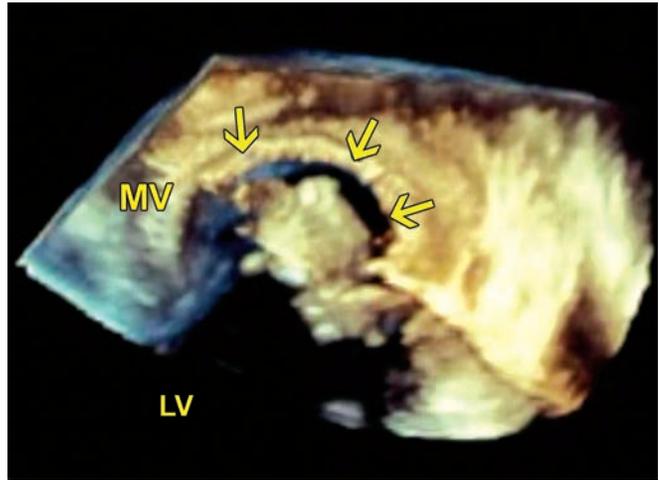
Three-dimensional imaging confirms evidence of the leaflet perforations (arrows) which correlate with the high-velocity valvular regurgitant jets visualized on color Doppler.
